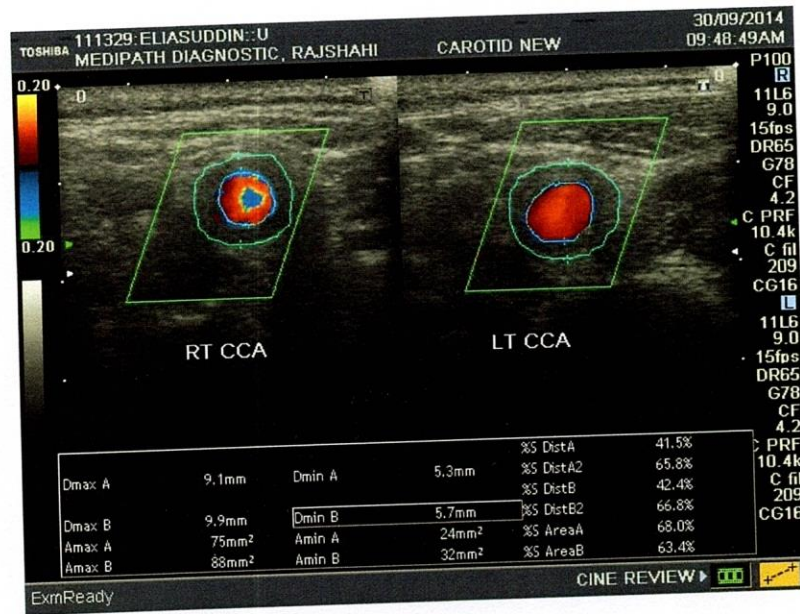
Assessment of Carotid Stenosis on B mode and Color Doppler image.
